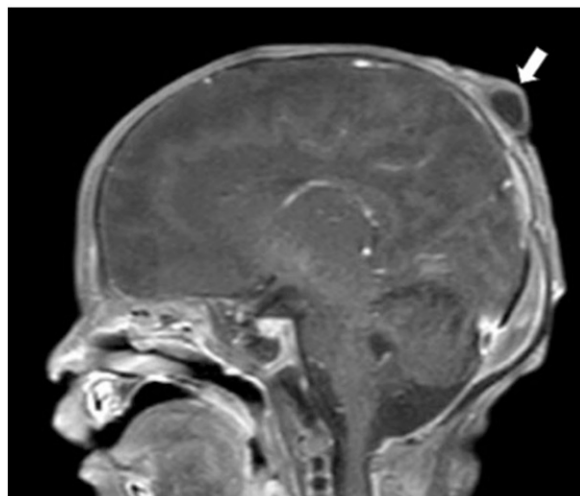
Cystic scalp lesion visualized on sagittal T1-weighted magnetic resonance imaging scan.
